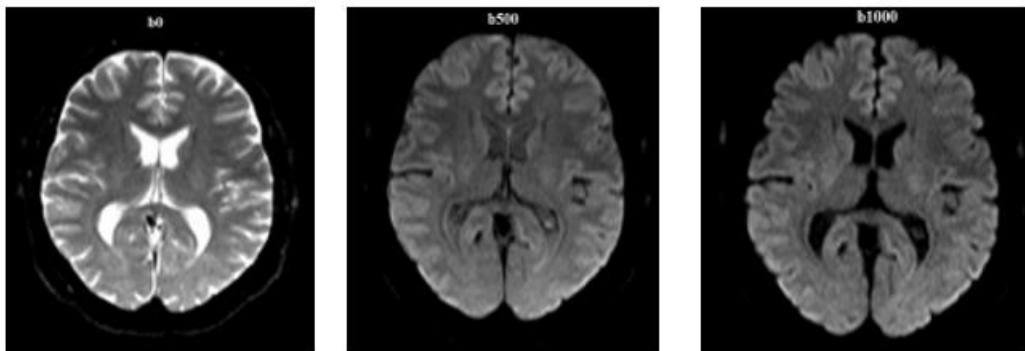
Example of DWI of different  $b$  value.
